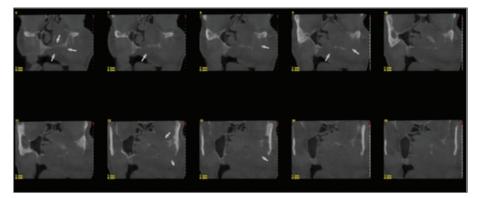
Cone beam computed tomography examination of the patient.
